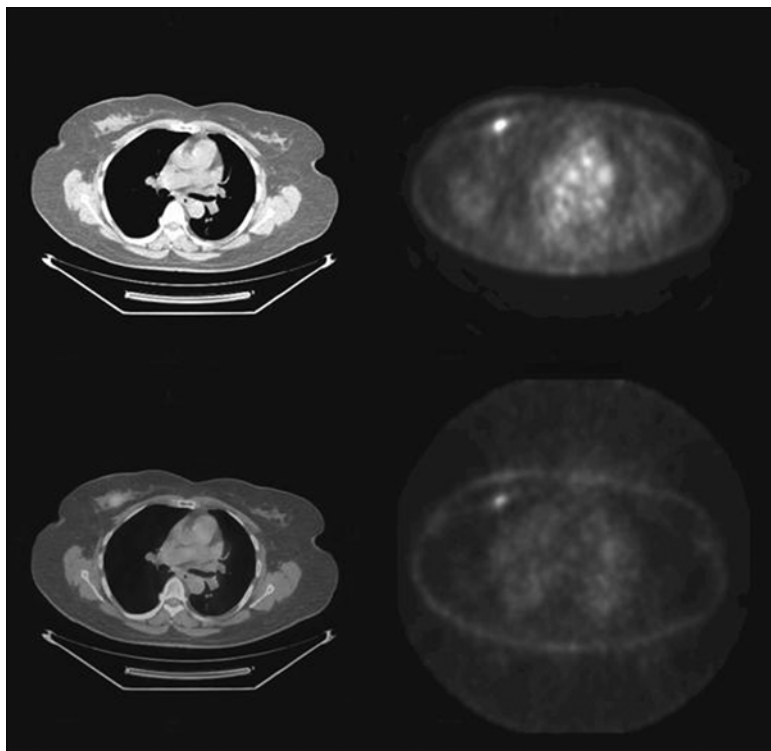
A 75-year-old woman who presented with a breast mass that was biopsied and demonstrated to be invasive ductal cancer. She was referred for a PET scan for initial staging, which was negative for disease other than the primary lesion in the right breast. The CT scan (upper left) reveals a right breast mass that is FDG avid on PET (upper right). The fused images (lower left) show the location of the cancer within the mass. The lower right image is the non-attenuation-corrected image.
